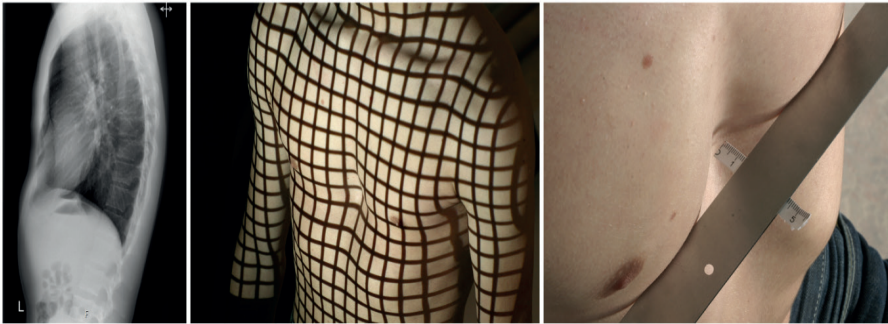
Patient A. Preoperative lateral plain chest radiograph, 3D grid stereogram and analogous measurement of external pectus depth.
